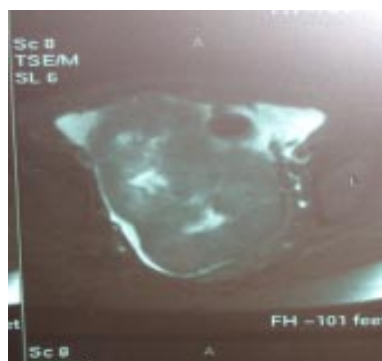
MRI pelvis showing heterogenous pelvic mass
